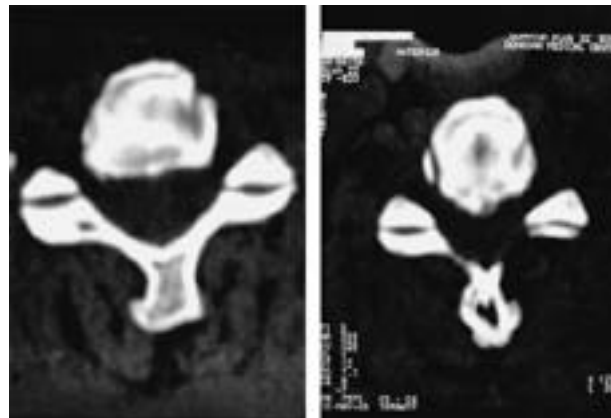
The CT discograms at C4-5 and C5-6 reveal circumferential tear and dye leakage.
